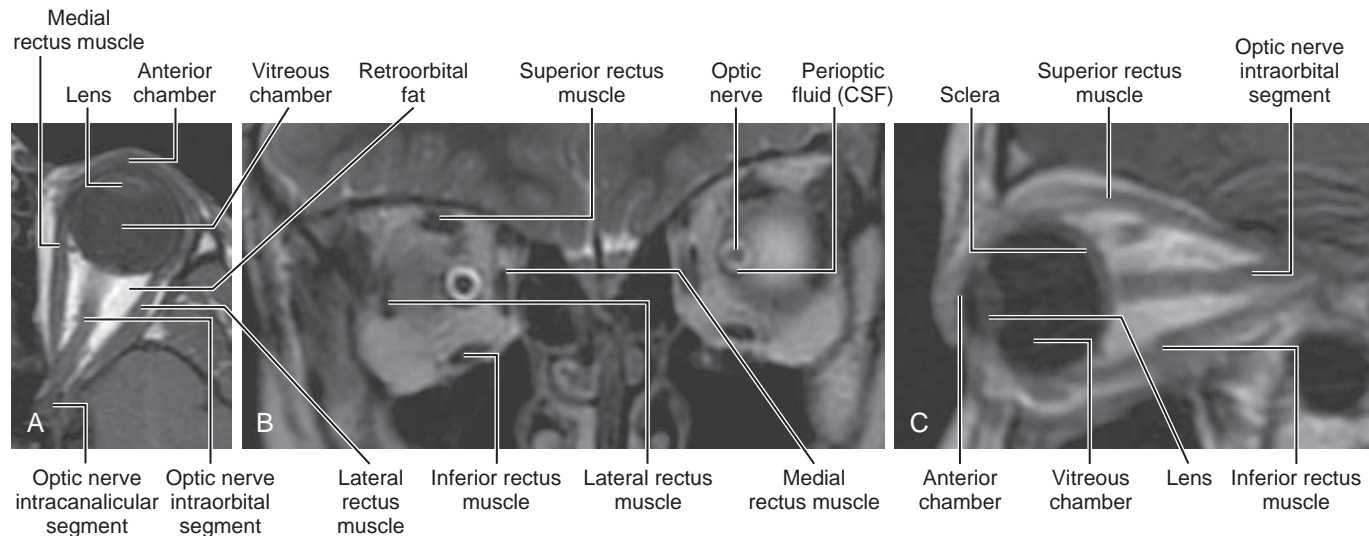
Orbital anatomy on MRI. (A) Axial T1-weighted image. (B) Coronal T2-weighted image. (C) Sagittal oblique T1-weighted image. CSF, Cerebrospinal fluid.
